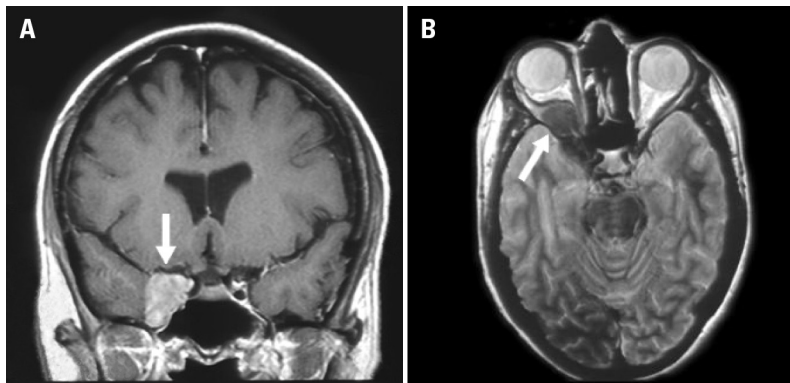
[A] Enhanced coronal T1-weighted imaging showing a right parassellar lesion (with extension to the cavernous sinus), with intense homogeneous enhancement. [B] Axial T2: hypointense intraconal lesion with intracranial extension.
